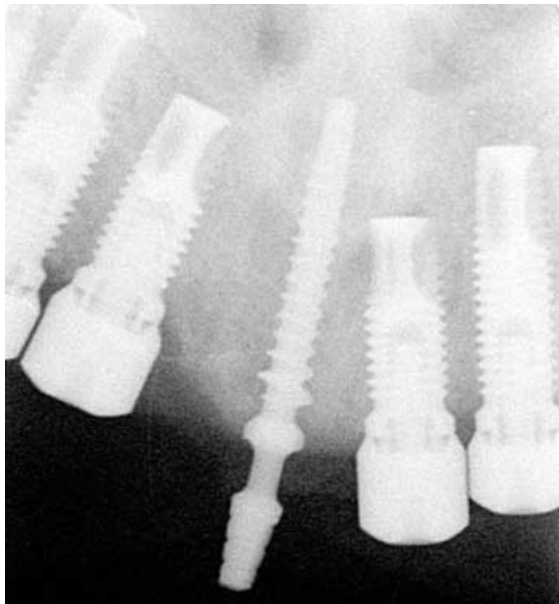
Postoperative radiograph of IPI and adjacent implants.
